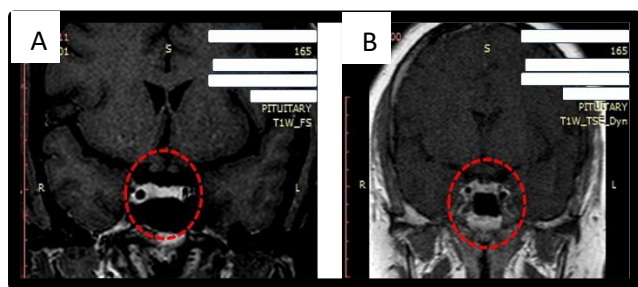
(A and B): MRI of pituitary microadenoma.
